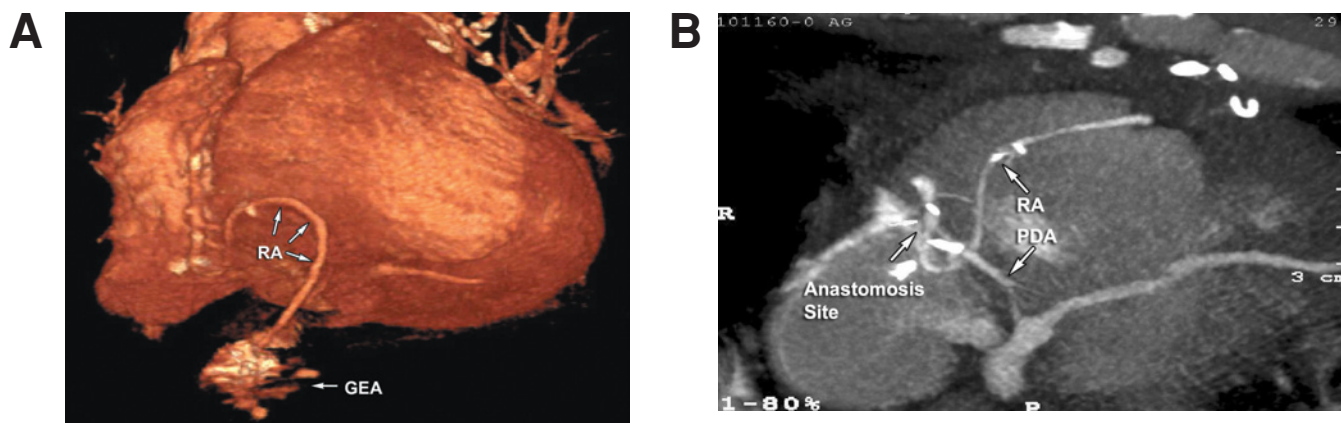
Three-dimensional volume rendered computed tomographic image of the heart showing the new free radial artery (RA) connected proximally to the right gastroepiploic artery (RGEA).
